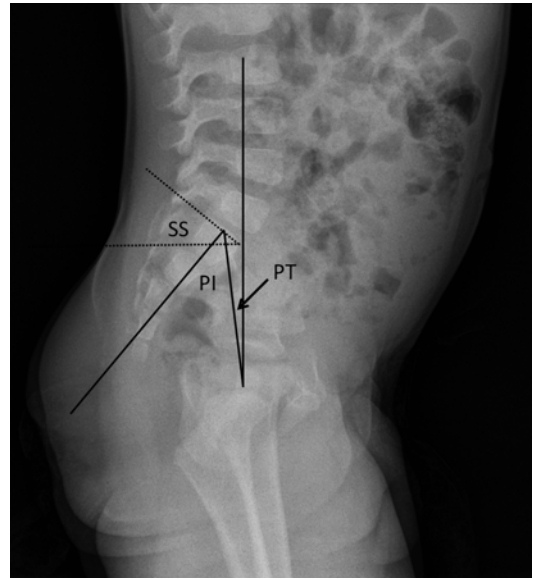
Radiograph of a skeletally immature patient demonstrating sagittal plane pelvic parameters. *PI* pelvic incidence, *PT* pelvic tilt, *SS* sacral slope
